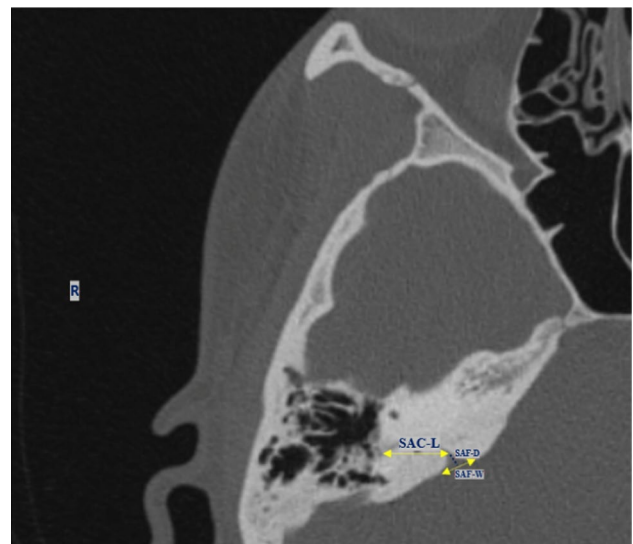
CT Scan of the right side of the cranium. *SAC-L* Length of the subarcuate canal, *SAF-W* Width of subarcuate fossa, *SAF-D* Depth of subarcuate fossa
